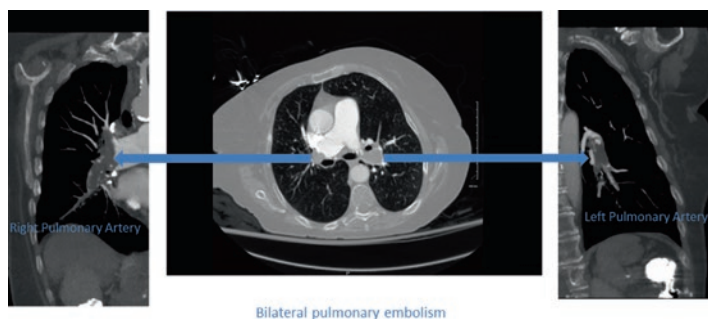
A computed tomographic pulmonary angiogram demonstrating a saddle pulmonary embolism. The blue arrows show the extension of the clot into bilateral pulmonary arteries
